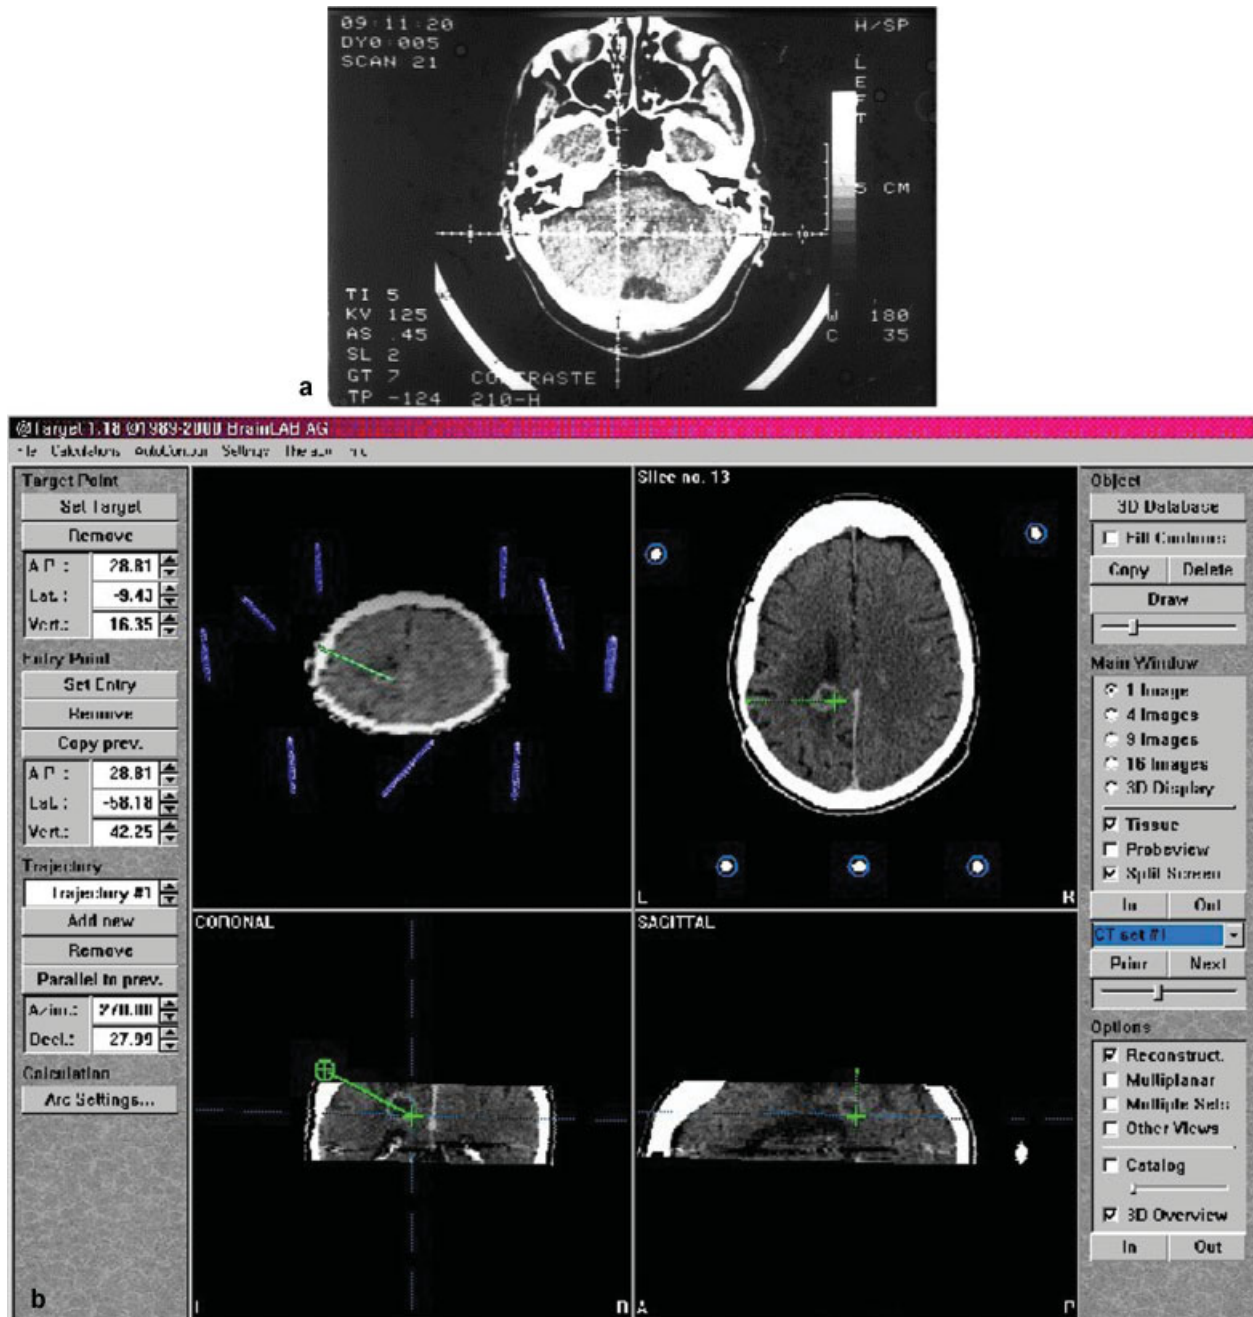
Period 2 (1991–2011) surgical planning. (a) Computed tomography software calculations. (b) Calculations with Target v.1.19 program (Brainlab).
